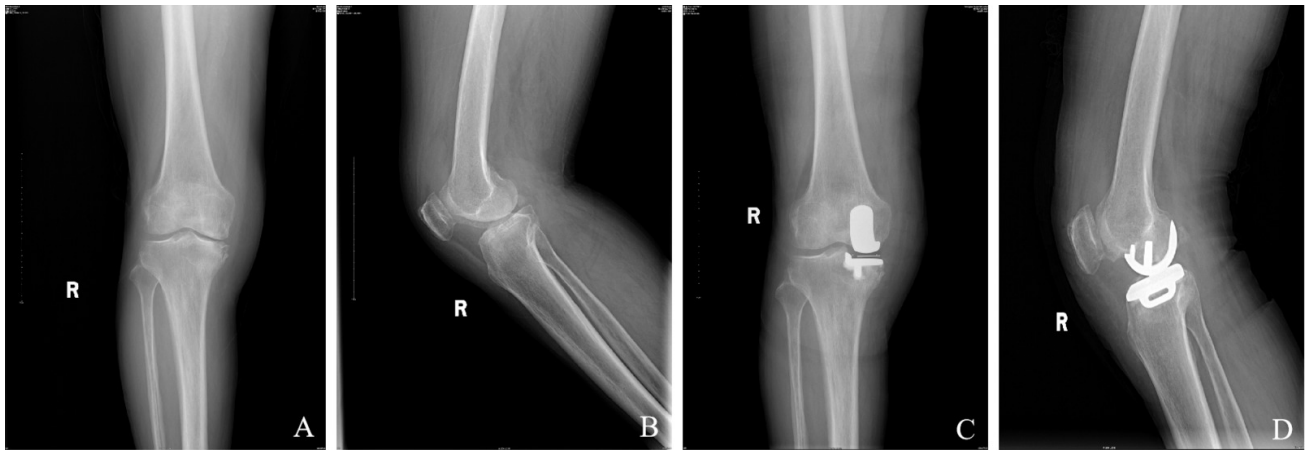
A: Preoperative anteroposterior radiograph of the knee before UKA; B: Preoperative lateral radiograph of the knee before UKA; C: Anteroposterior radiograph of the knee on postoperative day 1 after UKA; D: Lateral radiograph of the knee on postoperative day 1 after UKA.
